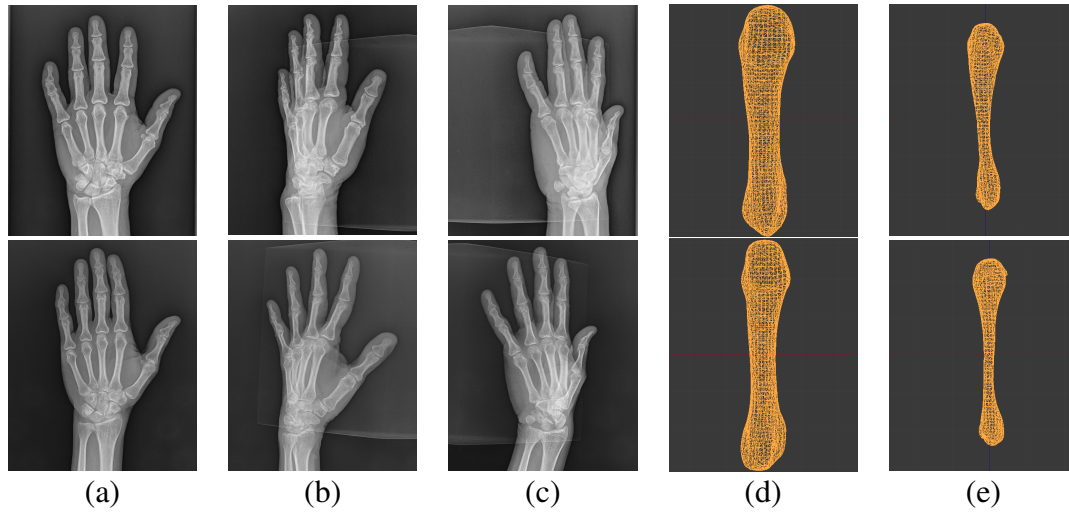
Examples of the 3D reconstructed models of the outer and inner bones of the third metacarpal bone for a healthy subject (top row) and a subject with LBM (bottom row) : (a) Hand X-ray image in PA view, (b) hand X-ray image in oblique 45° view, (c) hand X-ray image in oblique 135° view, (d) reconstructed outer bone model and (e) reconstructed inner bone model of the third metacarpal bone using the proposed method. Cortical volumetric measurements of the 3D reconstructed bone shaft are as follows: Healthy subject (top row: $CV = 878.71 \text{ mm}^3$, $CV_{OV} = 0.7672$, $CV_{SA} = 0.6148 \text{ mm}$, $CV_n = 0.0330$), and subject with LBM (bottom row: $CV = 624.64 \text{ mm}^3$, $CV_{OV} = 0.8287$, $CV_{SA} = 0.5853 \text{ mm}$, $CV_n = 0.0314$).
